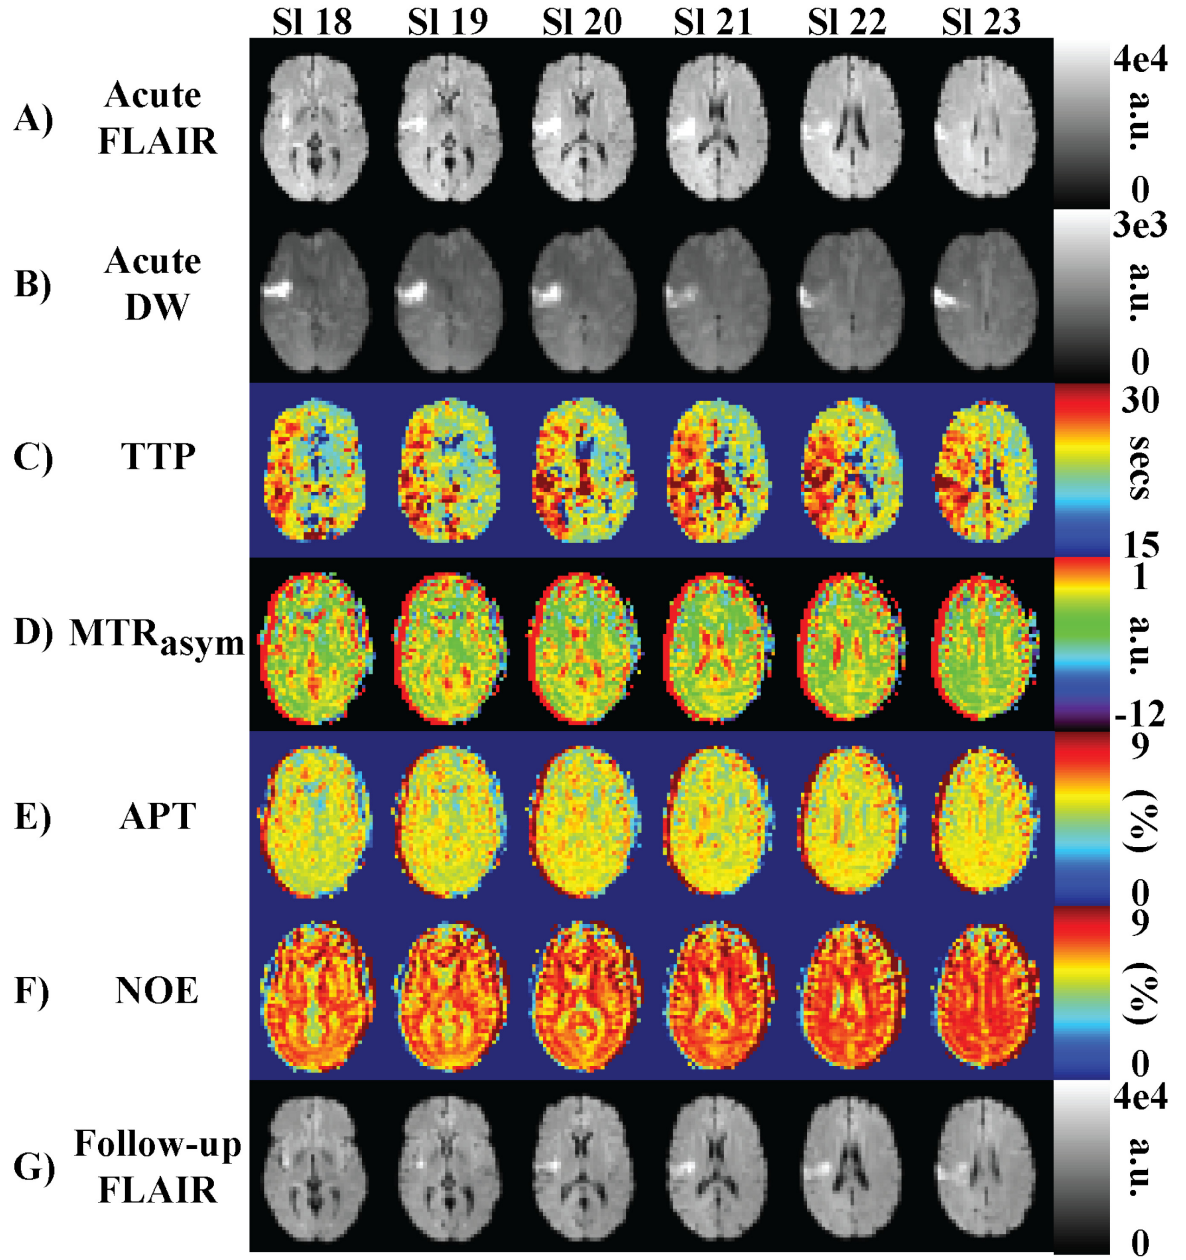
Slices 18 to 23 for Patient 1. (A) Acute FLAIR scan. (B) Acute mean diffusion weighted image. (C) Time-to-peak image. (D)  $MTR_{asymmetry}(3.5 \text{ ppm})$ . (E) APT. (F) NOE (G) Follow-up FLAIR.
